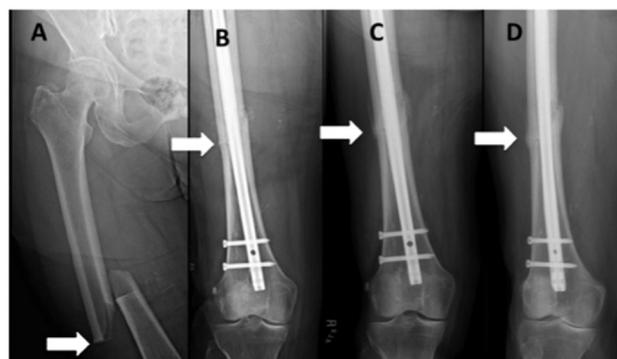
An AFF of the femoral diaphysis (courtesy of Fergus McKiernan). (A) Note the transverse fracture line in the lateral cortex that becomes oblique as it progresses medially across the femur (white arrow). (B) On radiograph obtained immediately after intramedullary rod placement, a small area of periosteal thickening of the lateral cortex is visible (white arrow). (C) On radiograph obtained at 6 weeks, note callus formation at the fracture site (white arrow). (D) On radiograph obtained at 3 months, there is mature callus that has failed to bridge the cortical gap (white arrow). Note the localized periosteal and/or endosteal thickening of the lateral cortex at the fracture site (white arrow).
